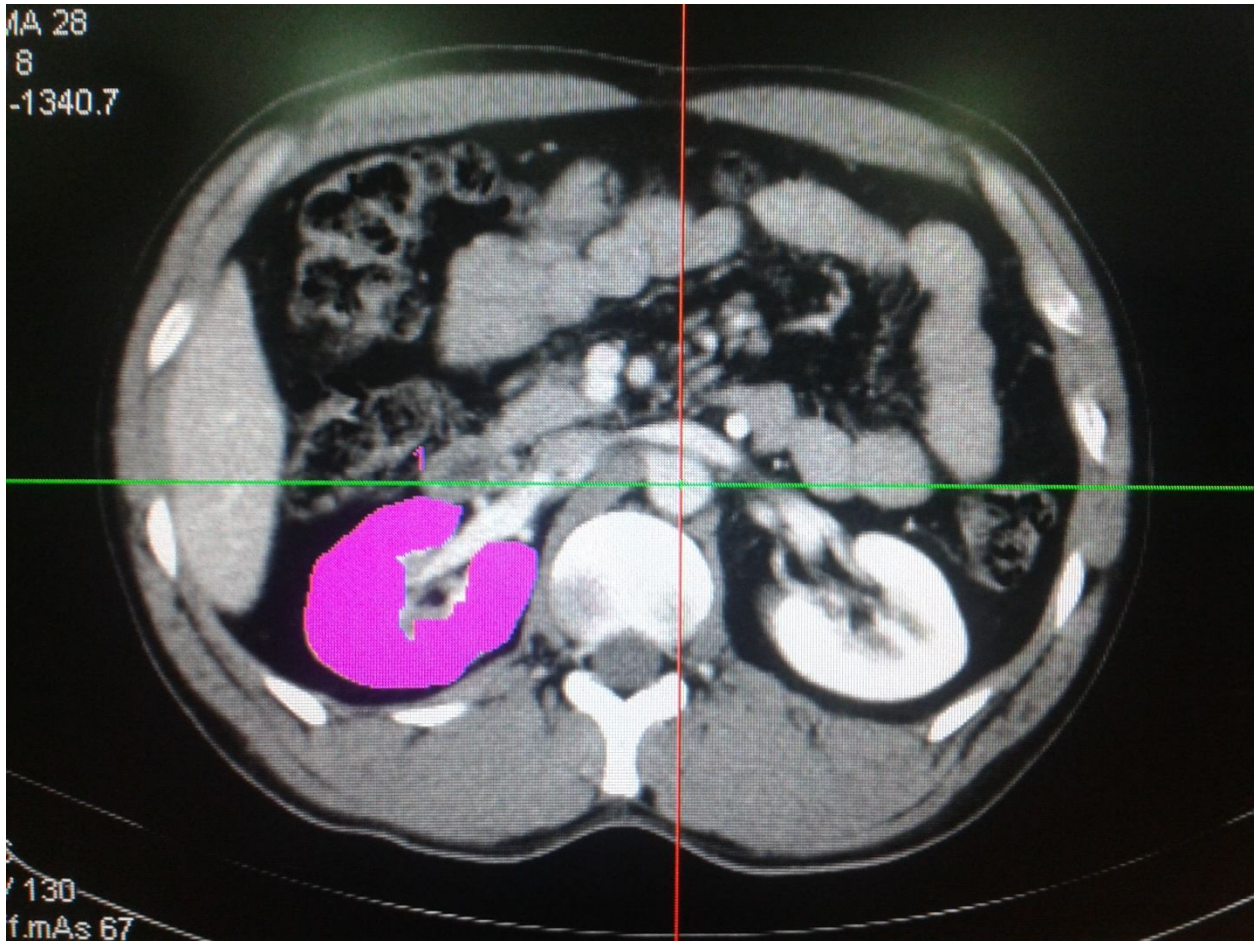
Method 2 - Intra venous contrast enhanced CT axial sections of the abdomen at the level of the kidneys demonstrating manually corrected region of interest drawn on the right kidney as in Relative Mean Attenuation Capacity Method. Note that the color shaded area includes normal enhancing renal parenchyma and excludes hilar fat and blood vessels.
